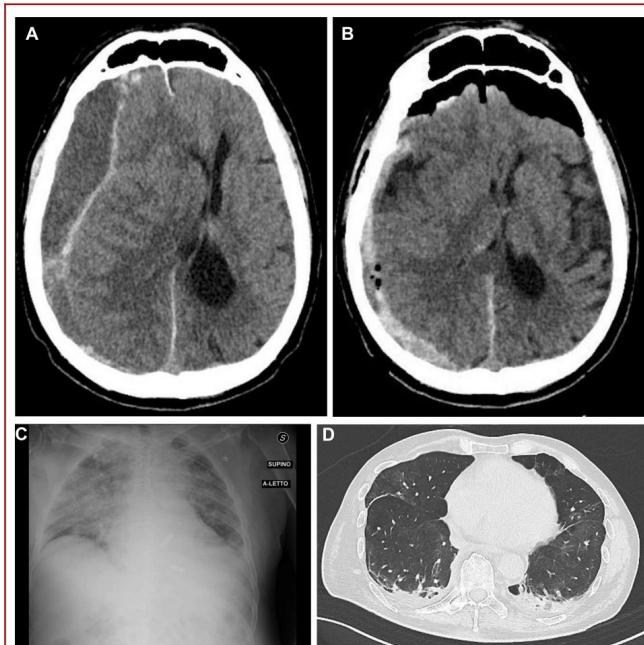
A. Head CT scan, axial view: preoperative CSDH. B. Head CT scan, axial view: postoperative CSDH with signs of recent rebleeding. C. CXR showing bilateral IP. D. Chest CT scan, axial view, showing ground glass opacity.
